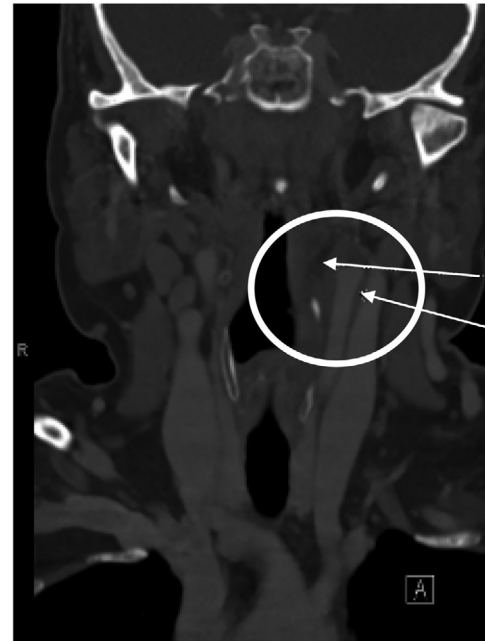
TIPIC syndrome on the coronal plane of the CTA neck. Arrows identify evidence of circumferential thickening of the distal left common carotid artery. Abbreviations: CTA, computed tomography angiography; TIPIC, transient perivascular inflammation of the carotid artery.
